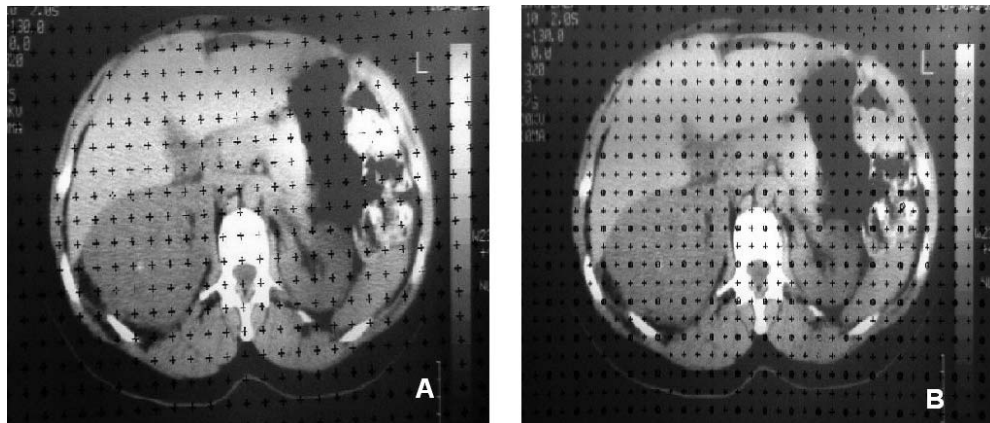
A Stereological Test System Superimposed over CT Sections through the Kidney, to Estimate RCC Tumor Volume (A) and Tumor Ratio (B)
